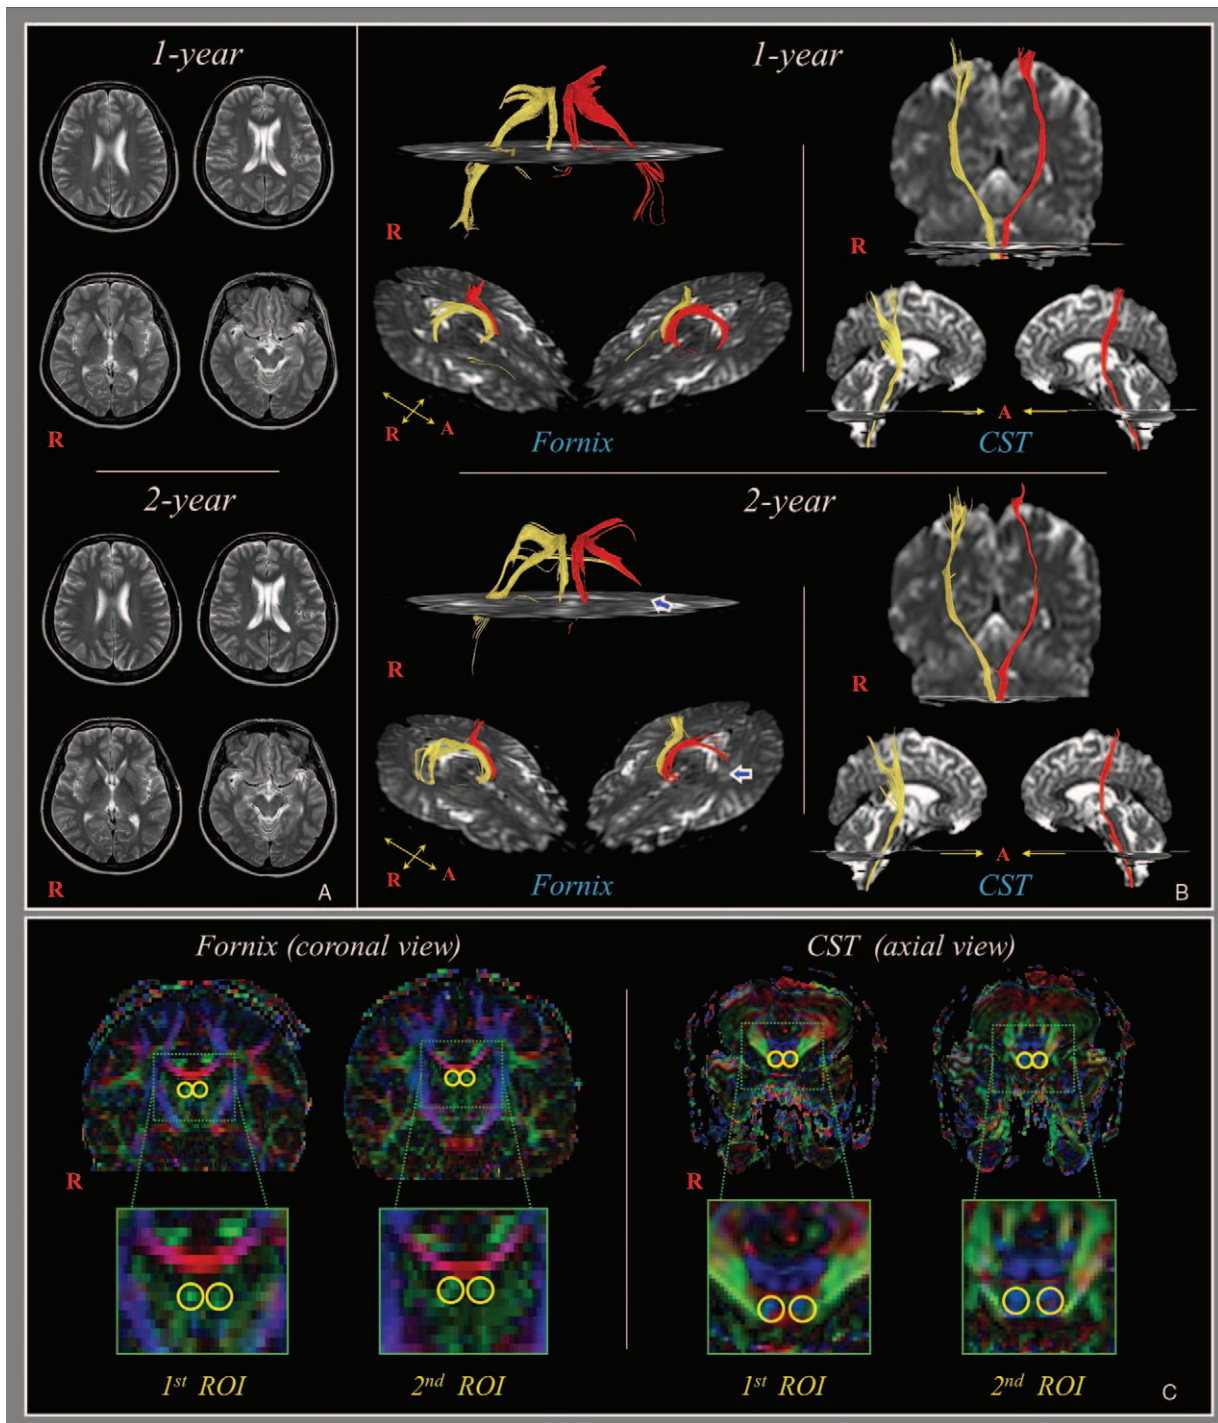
(A) T2-weighted magnetic resonance images taken at 1-year and 2-year after onset showed no specific lesions. (B) Diffusion tensor tractography (DTT) of the fornix. The integrity of the fornix is well preserved between the fornical column and fornical crus on 1-year DTT. By contrast on 2-year DTT, a discontinuation (arrows) is observed in the left fornical crus. DTT = diffusion tensor tractography.
